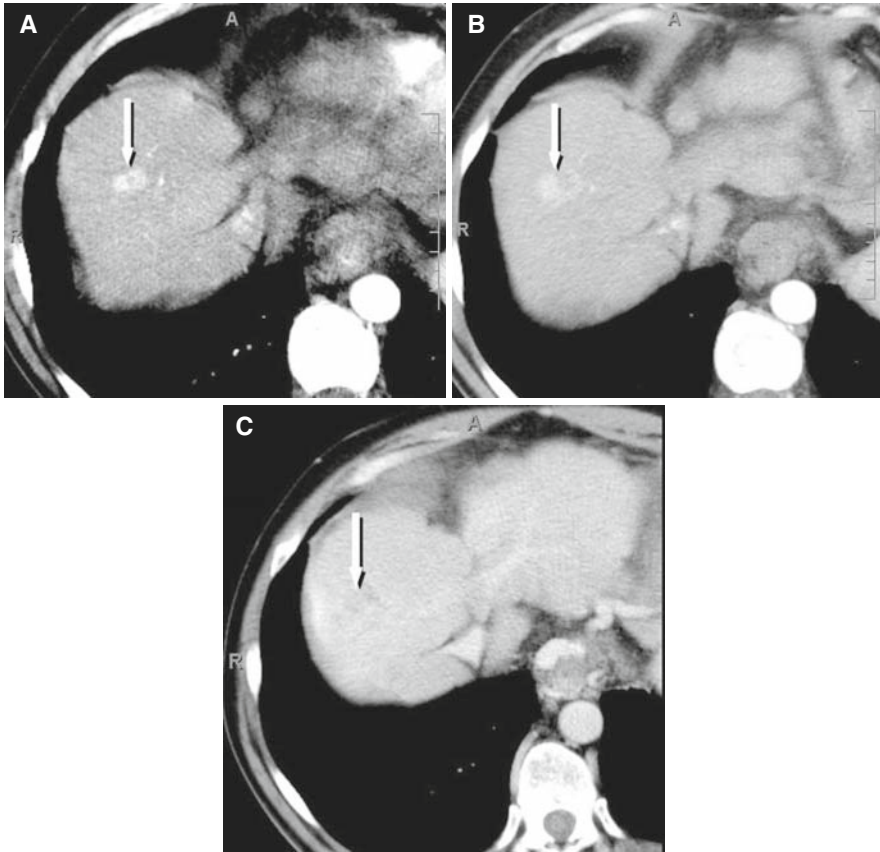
Surveillance for HCC. (A) Arterial phase CT shows tiny enhancing lesion (*arrow*) which is difficult to distinguish between small HCC and arterioportal shunting. (B) Arterial phase CT obtained after 5 months. The nodule (*arrow*) has increased in size. (C) Portal venous phase CT. The HCC (*arrow*) is now slightly hypodense to liver.
